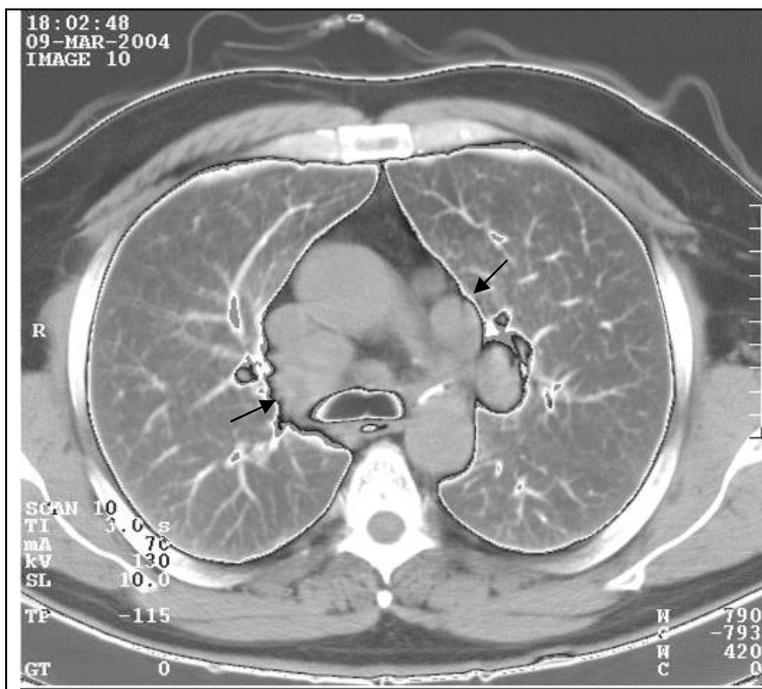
CT-scan at a level of a bifurcation of a trachea. Enlarged lymph nodes without a calcification in a mediastinum (arrows). Hodgkin's lymphoma.
